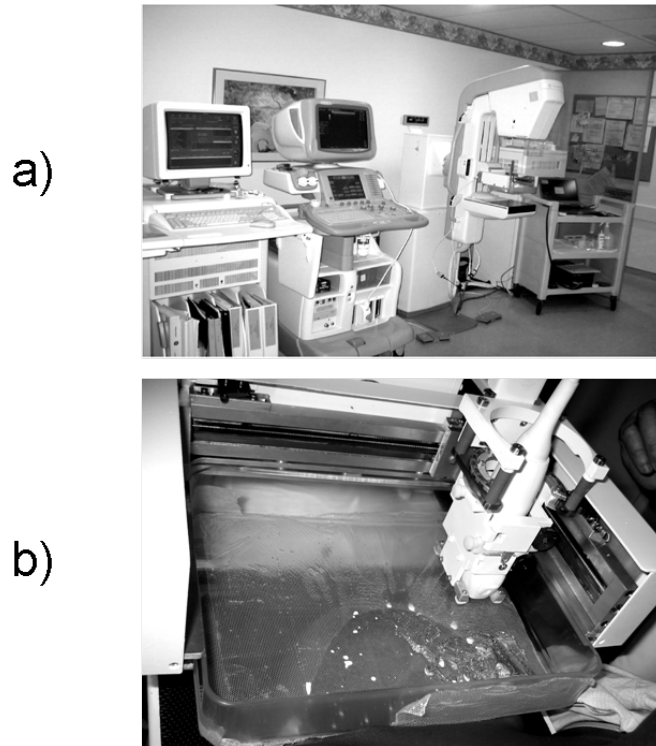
a) Combined 3D ultrasound/ digital mammography system. From left to right are the mammogram storage unit, GE LOGIQ 9 scanner, Senographe 2000D digital mammography unit, and cart containing hardware and software to drive the combined system. b) Close up view of a breast compressed between the mammographic paddle and x-ray detector, with the ultrasound transducer and holder attached.
